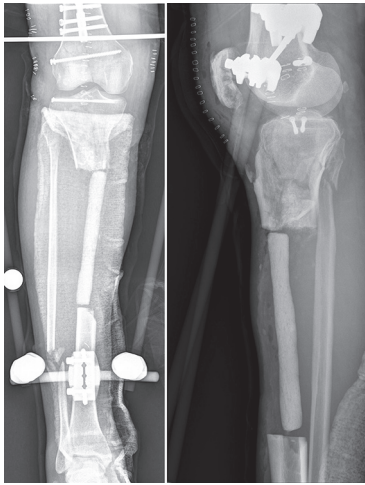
A/P and lateral radiographs of the right tibia after debridement and irrigation, planing of the fracture ends, antibiotic-impregnated cement spacer placement, and external fixator placement demonstrating a 185 mm defect
